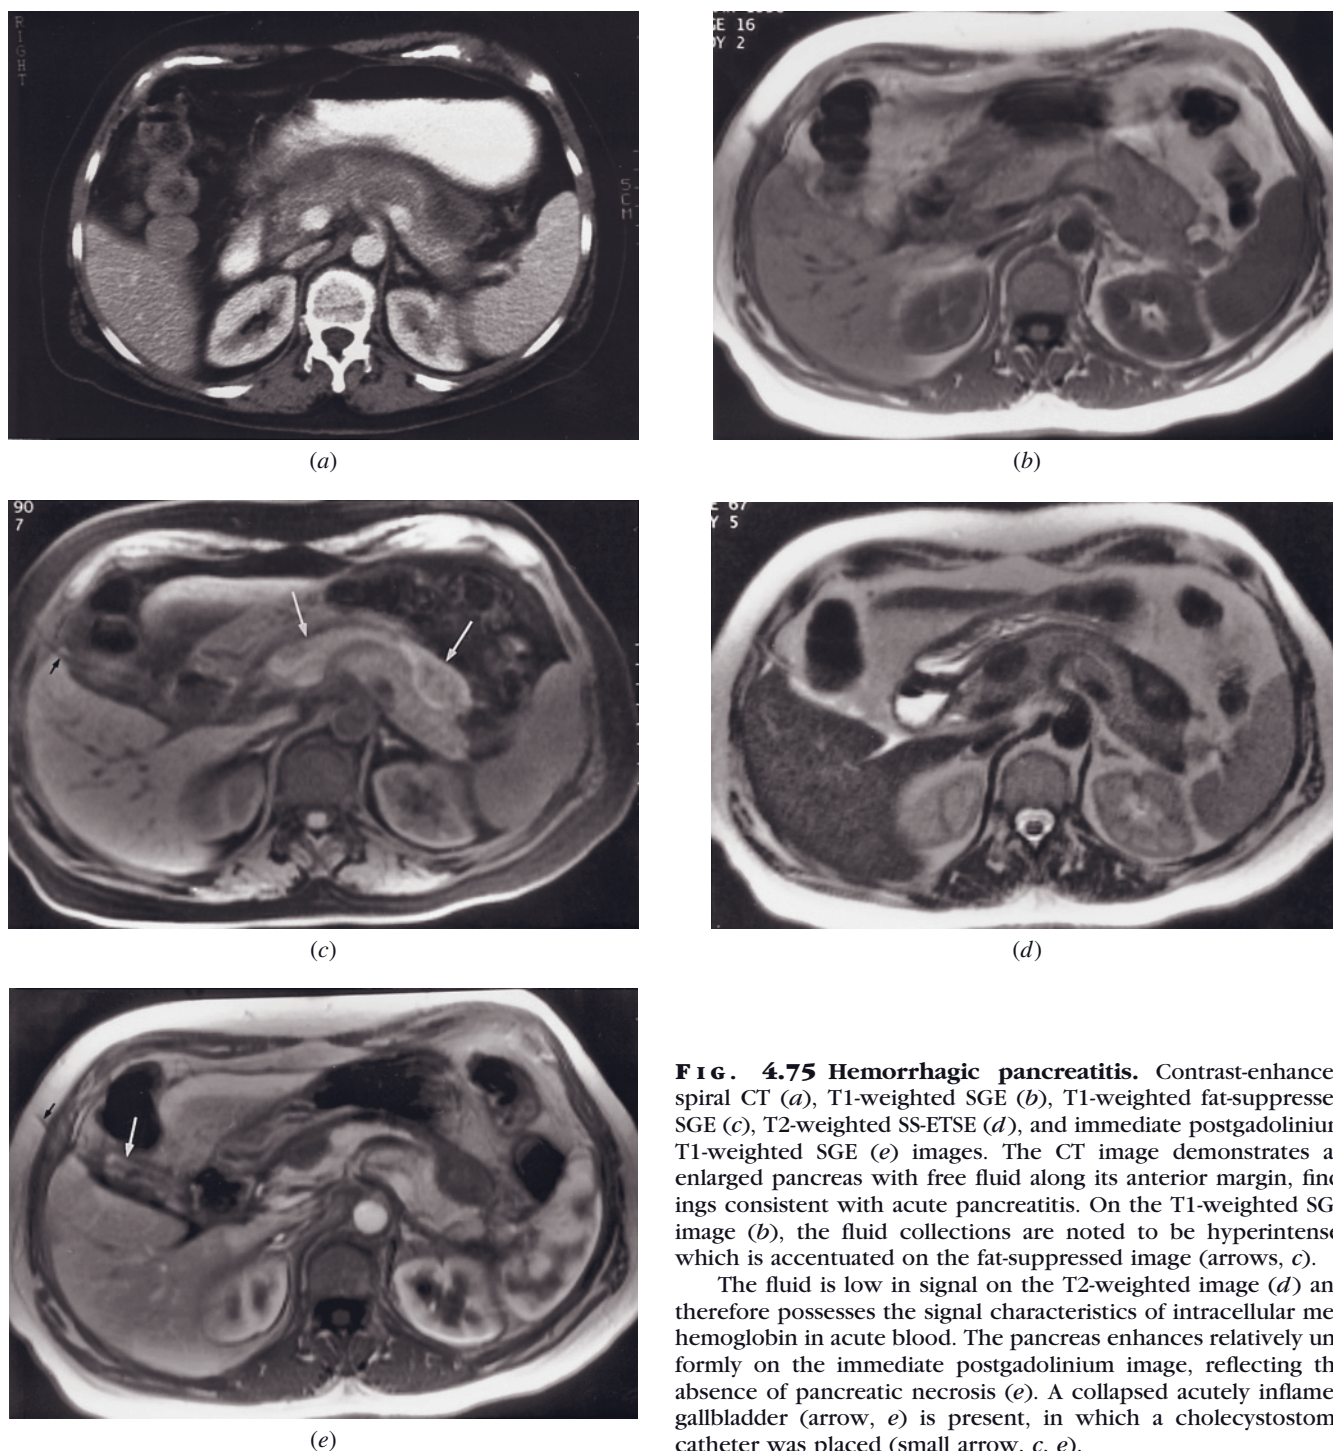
Hemorrhagic pancreatitis. Contrast-enhanced spiral CT (*a*), T1-weighted SGE (*b*), T1-weighted fat-suppressed SGE (*c*), T2-weighted SS-ETSE (*d*), and immediate postgadolinium T1-weighted SGE (*e*) images. The CT image demonstrates an enlarged pancreas with free fluid along its anterior margin, findings consistent with acute pancreatitis. On the T1-weighted SGE image (*b*), the fluid collections are noted to be hyperintense, which is accentuated on the fat-suppressed image (arrows, *c*).
